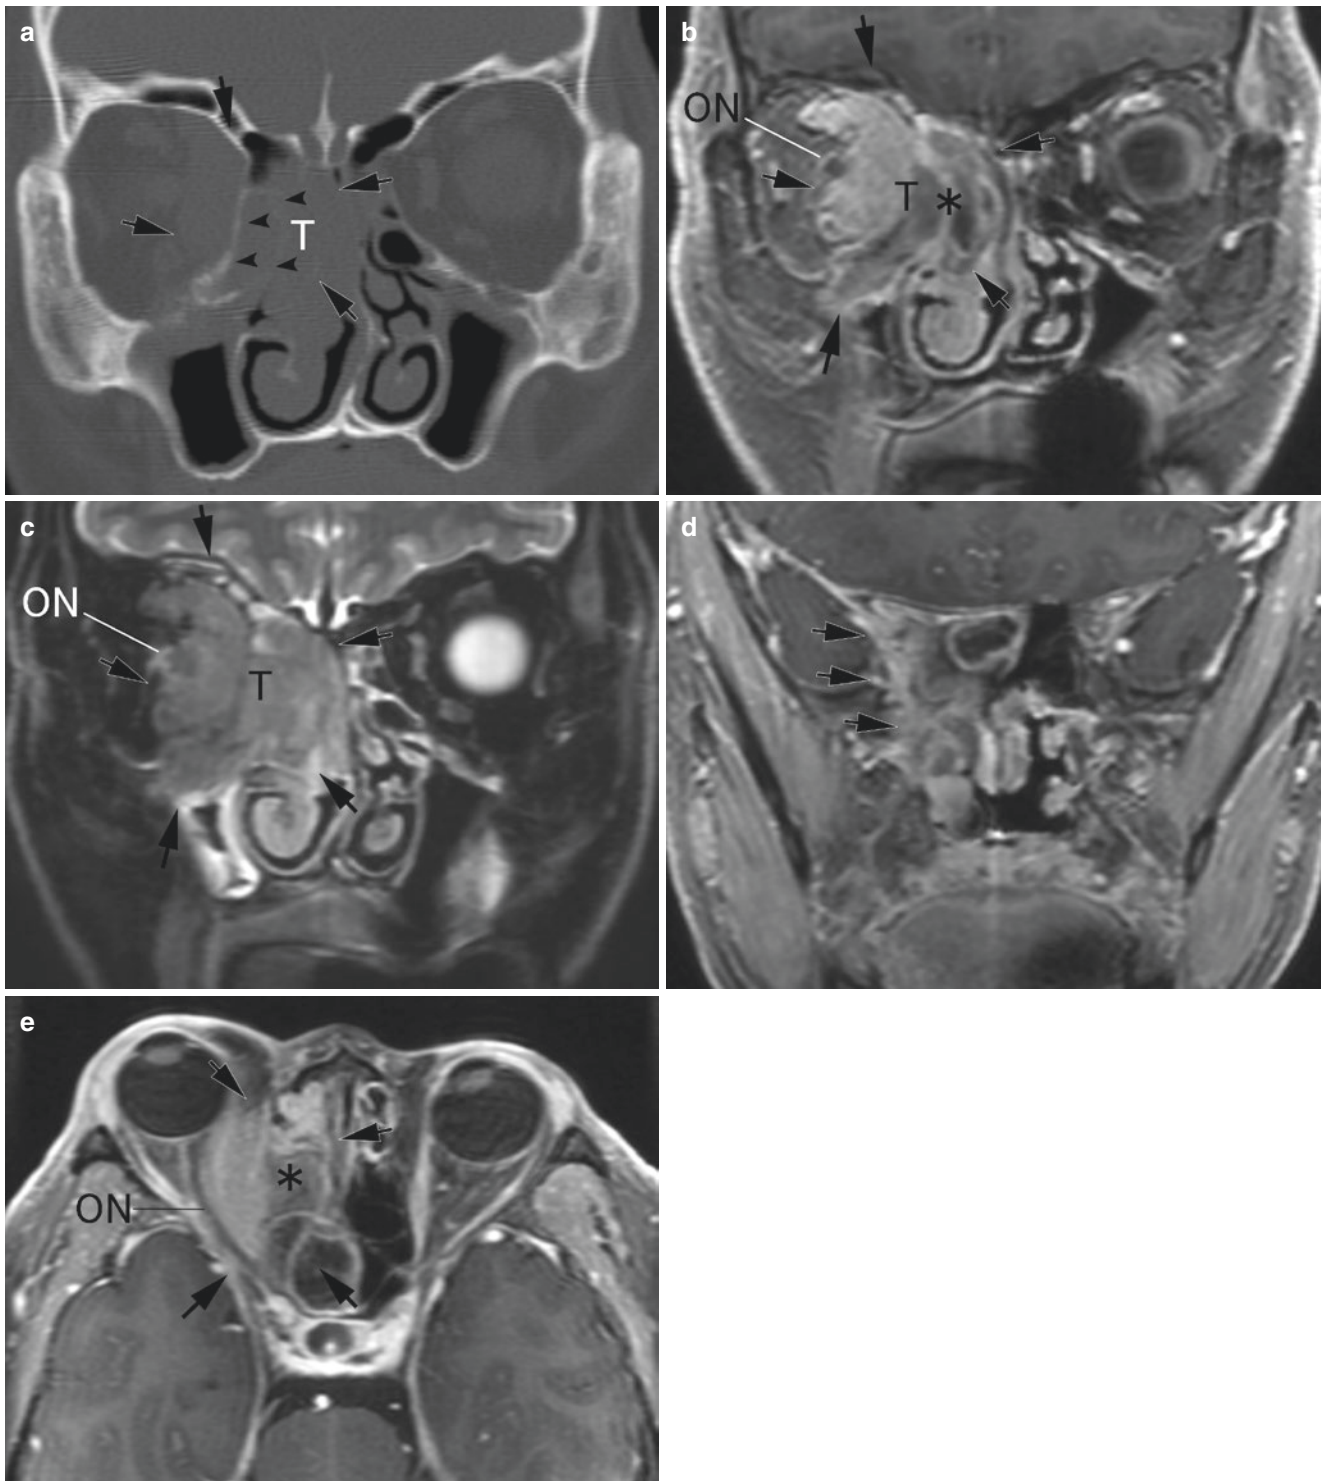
Squamous cell carcinoma of the ethmoid sinus. (a) CT bone algorithm. (b) Coronal Gd-enhanced T1-weighted image. (c) Coronal fat-suppressed T2-weighted image. (d) Coronal Gd-enhanced T1-weighted image. (e) Axial Gd-enhanced T1-weighted image. A tumorous lesion (T) is found extending from the right ethmoid sinus to the orbit and destroying the lamina papyracea (arrows). The medial walls of both the infraorbital and maxillary sinuses show osteolytic
